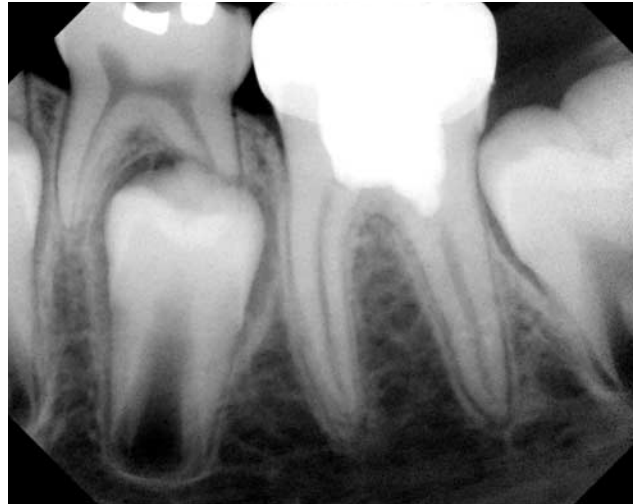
Postoperative radiograph of case no. 16 at 18-month recall (healed).
